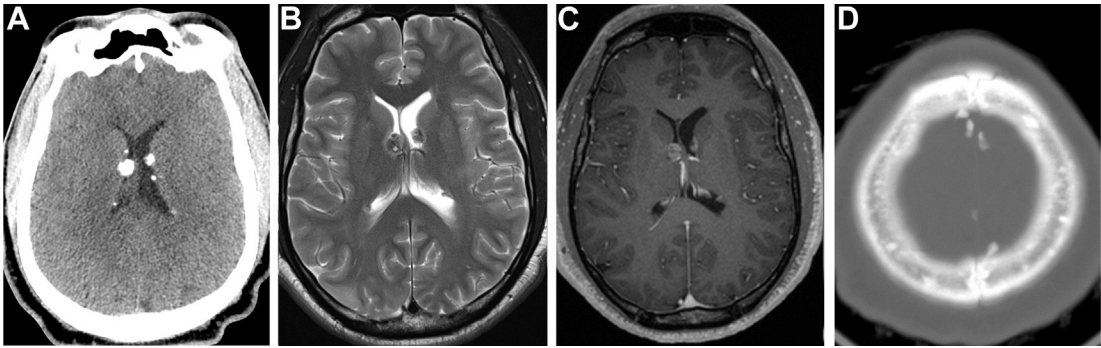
A 34-year-old patient with TS. (A) Axial CT, (B) T2WI, and (C) postcontrast T1WI show calcified multiple SENs with low T2 signal and postcontrast enhancement. (D) Axial CT bone window shows multiple sclerotic foci in the calvarium.
